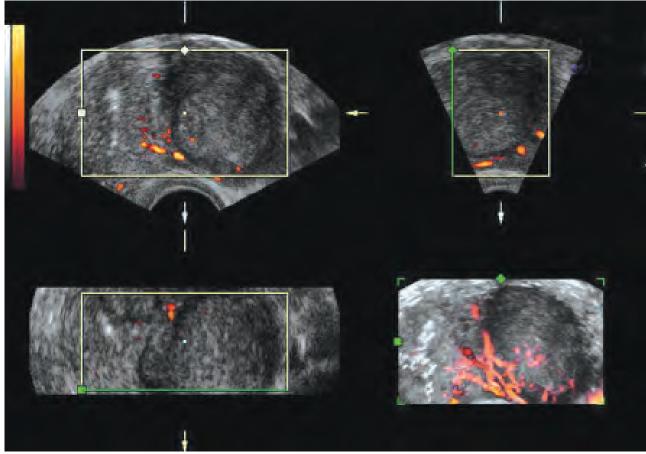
The three dimensional power Doppler ultrasound of the subserosal fibroid
